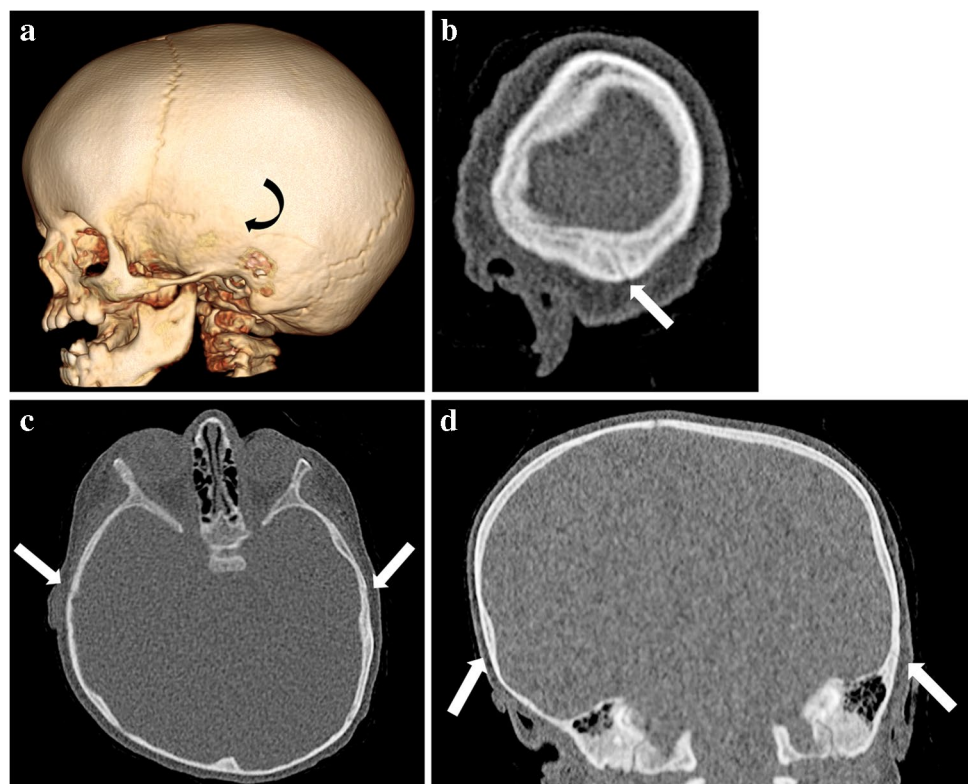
Patent cranial sutures in a 1-year-old girl. a, b Lower-dose computed tomography three-dimensional reformat viewed from the right posterior oblique (a) and axial bone (b) images demonstrate patent cranial sutures (*straight arrows*) and an area of calvarial thickening (*curved arrows*). c, d ventricles (*curved arrow*) seen on axial CT image (c) dysmorphism (*arrow*) seen on sagittal CT (d). Subsequent magnetic resonance imaging of the brain and spine were obtained (not shown) that better characterized the abnormalities, including features of campomelic dysplasia, platybasia, the partial absence of septum pellucidum, and diffuse thinning of central white matter and corpus callosum
